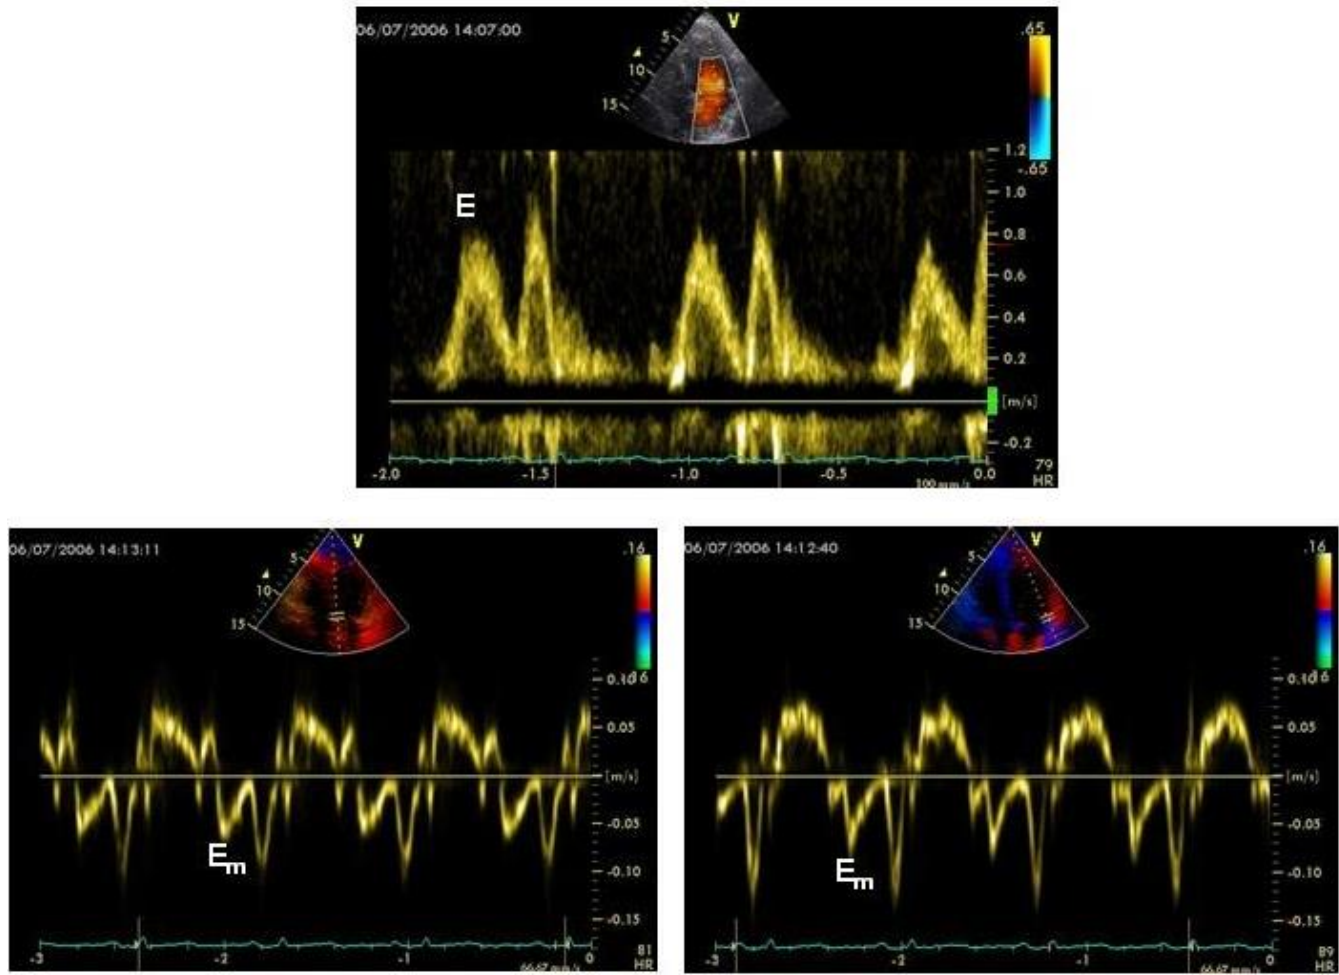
Doppler and tissue Doppler Changes in the anthracycline toxicity of the Heart.
